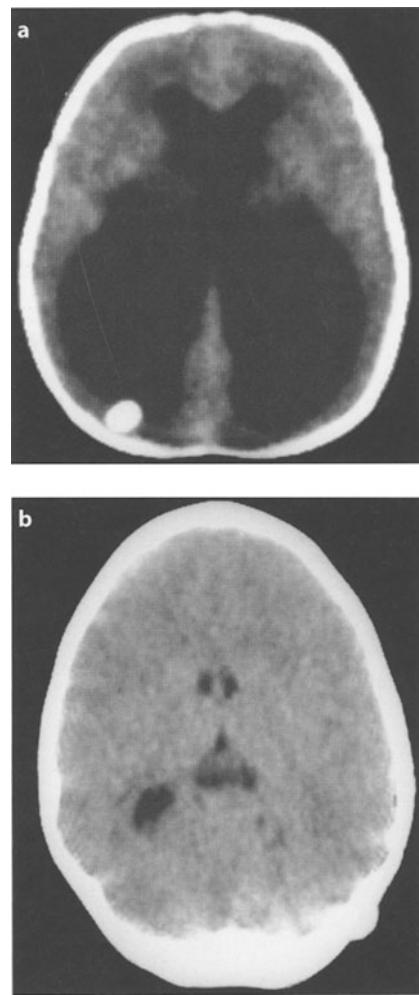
A 2-month-old baby premature girl with intraventricular hemorrhage. a CT scan at 2 months of age. Massive ventricular dilatation with cortical thinning. b Same patient at 2 years of age. The ventricles are narrow and the cortical mantle is normal
